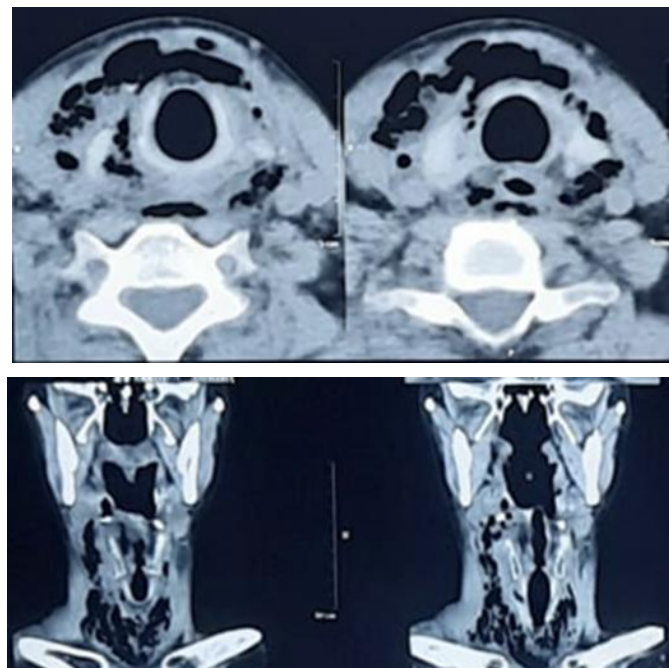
Cervical CT scan with the result of a hypodense lesion in the larynx area, retropharynx extending to the anterior colli and pretracheal regions.
